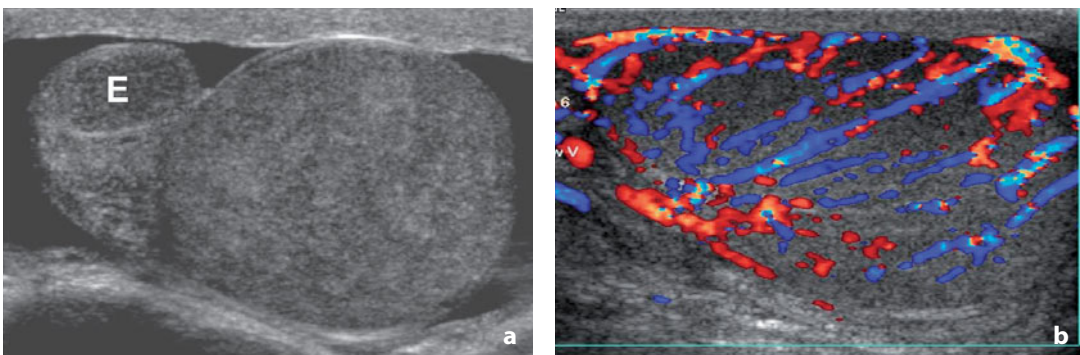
Orchiepididymitis. a Sonogram shows a mild enlargement of the head of epididymis (*E*) and the testis, which appears hypoechoic with heterogeneous echotexture. b The color Doppler study shows diffuse hypervascularity
